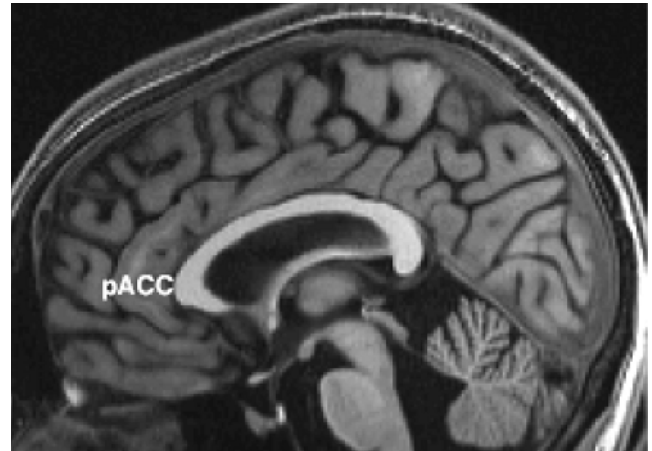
This magnetic resonance image shows the midsagittal (middle) surface of the human brain. Perigenual anterior singulate cortex (pACC) lies anterior to (in front of) the genu of the corpus callosum.
